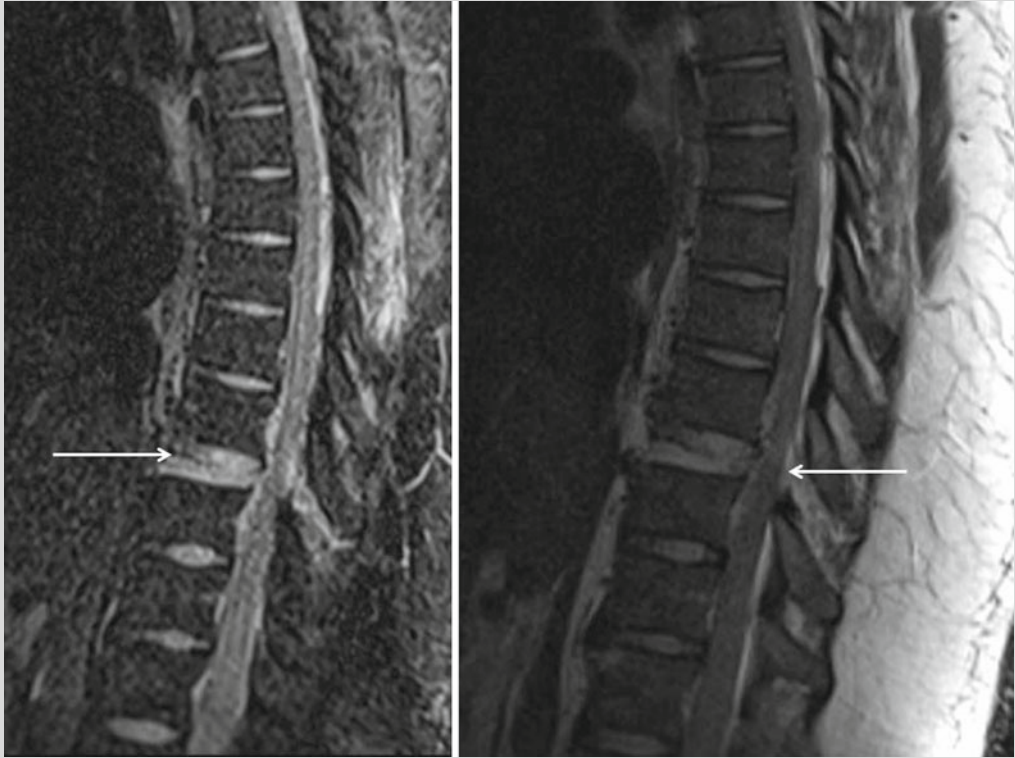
STIR sequence (*left*) and T2-weighted (*right*) magnetic resonance imaging (MRI) pictures demonstrating severe damage to the T9–10 segment with complete compromise of the intervertebral disk
